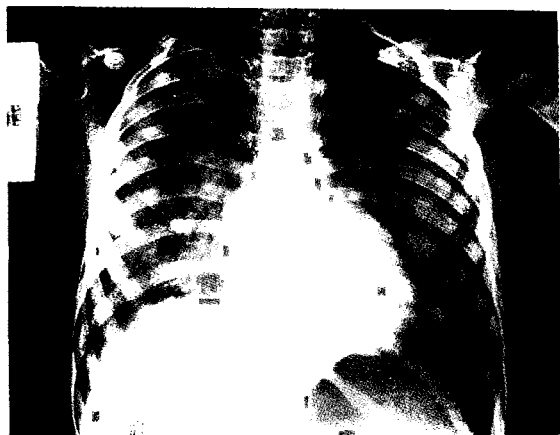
Anteroposterior chest roentgenogram of patient 4, obtained 6 hours after sting by *T. serrulatus*, showing enlarged heart and bilateral lung edema more severe over the right lung, with air bronchograms.
